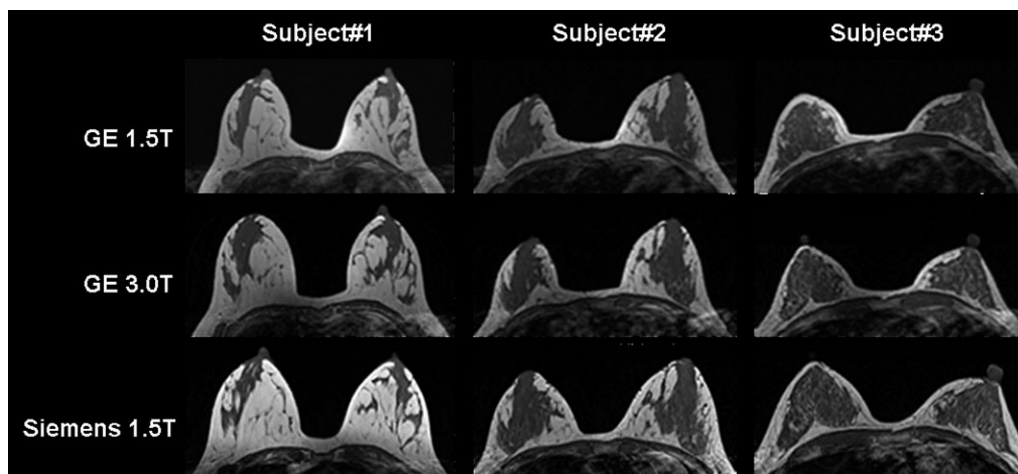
Representative T1W images of breast magnetic resonance imaging (MRI) from three subjects acquired using three MR scanners. They present different amount of dense tissues and different breast parenchymal morphological patterns. The coefficient of variation for the measurement of breast volume, fibroglandular tissue volume and percent density are 4.9%, 2.9% and 3.8%, respectively, for subject 1; 3.5%, 7.4% and 3.2%, respectively, for subject 2; and 3.9%, 7.1% and 9.4%, respectively, for subject 3.
